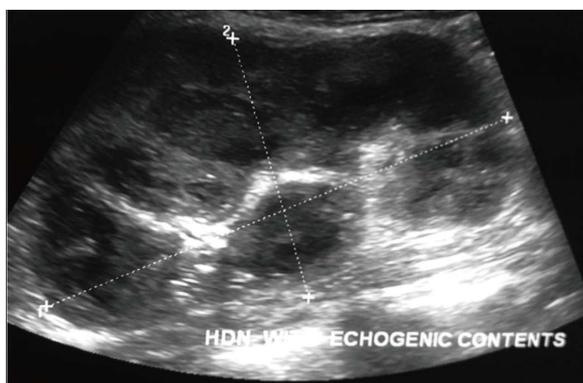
Ultrasonography shows hydronephrosis with echogenic debris within suggestive of pyonephrosis.
